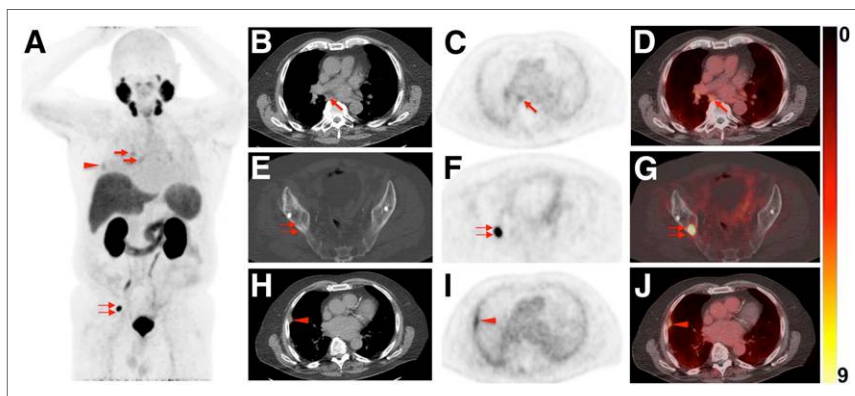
Images of 76-y-old man undergoing ^{18}F -DCFPyL PET/CT for staging of metastatic PCa (prostate-specific antigen level on date of scan, 0.63; prior prostatectomy). (A) Whole-body maximum-intensity projection shows radiotracer uptake in right hilar and subcarinal LNs (arrows), lung lesion (arrowhead), and right iliac bone (doubled arrow). (B–D) Axial CT (B), axial ^{18}F -DCFPyL PET (C), and axial ^{18}F -DCFPyL PET/CT (D) show mild to moderate radiotracer uptake in subcarinal LN (arrows). IR called this finding PSMA-RADS-4, whereas ER classified it PSMA-RADS-2 (i.e., likely benign because of low-level uptake in soft-tissue site atypical of metastatic PCa). Hilar and subcarinal LNs remained unchanged on follow-up imaging, suggesting that these are benign. All 4 readers classified overall scan impression as PSMA-RADS-5. (E–G) Axial CT (E), axial ^{18}F -DCFPyL PET (F), and axial ^{18}F -DCFPyL PET/CT (G) show intense radiotracer uptake in right iliac bone (doubled arrows). Apart from that, lung lesion (^{18}F -DCFPyL whole-body maximum intensity projection in A, red arrowhead) was classified as PSMA-RADS-2 by IR. (H–J) Axial CT (H), axial ^{18}F -DCFPyL PET (I), and axial ^{18}F -DCFPyL PET/CT (J) of this lesion further confirm suspicion of benign lesion (arrowheads, most likely peripheral interstitial thickening). Follow-up imaging also corroborated this impression.
